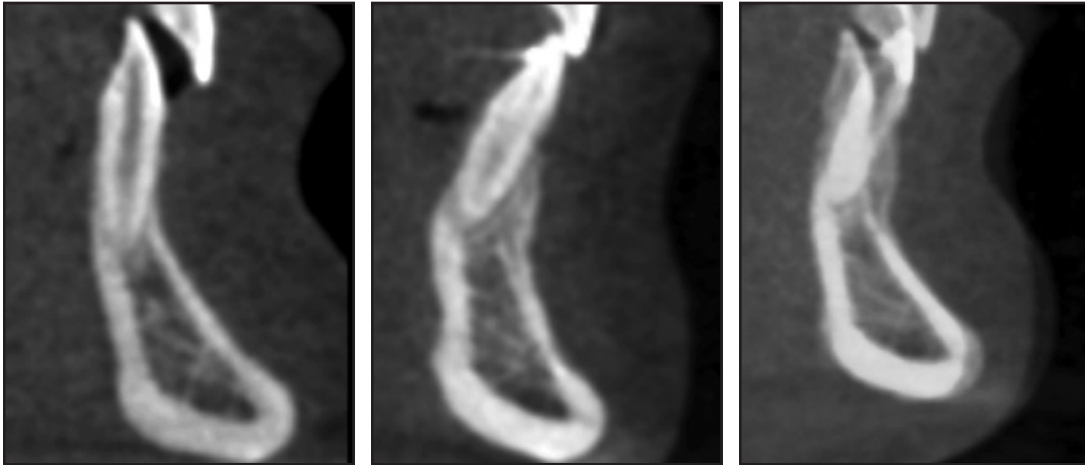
Case 3. CBCT images taken before and after treatment superimposed on internal cortex of mandibular symphysis, showing bony apposition on facial aspect of lower anterior teeth.
